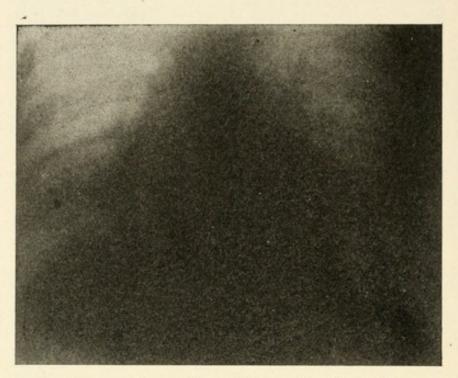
Angina pectoris. After half-hour of gentle resistance-exercises. (X-ray photograph of the heart.)
